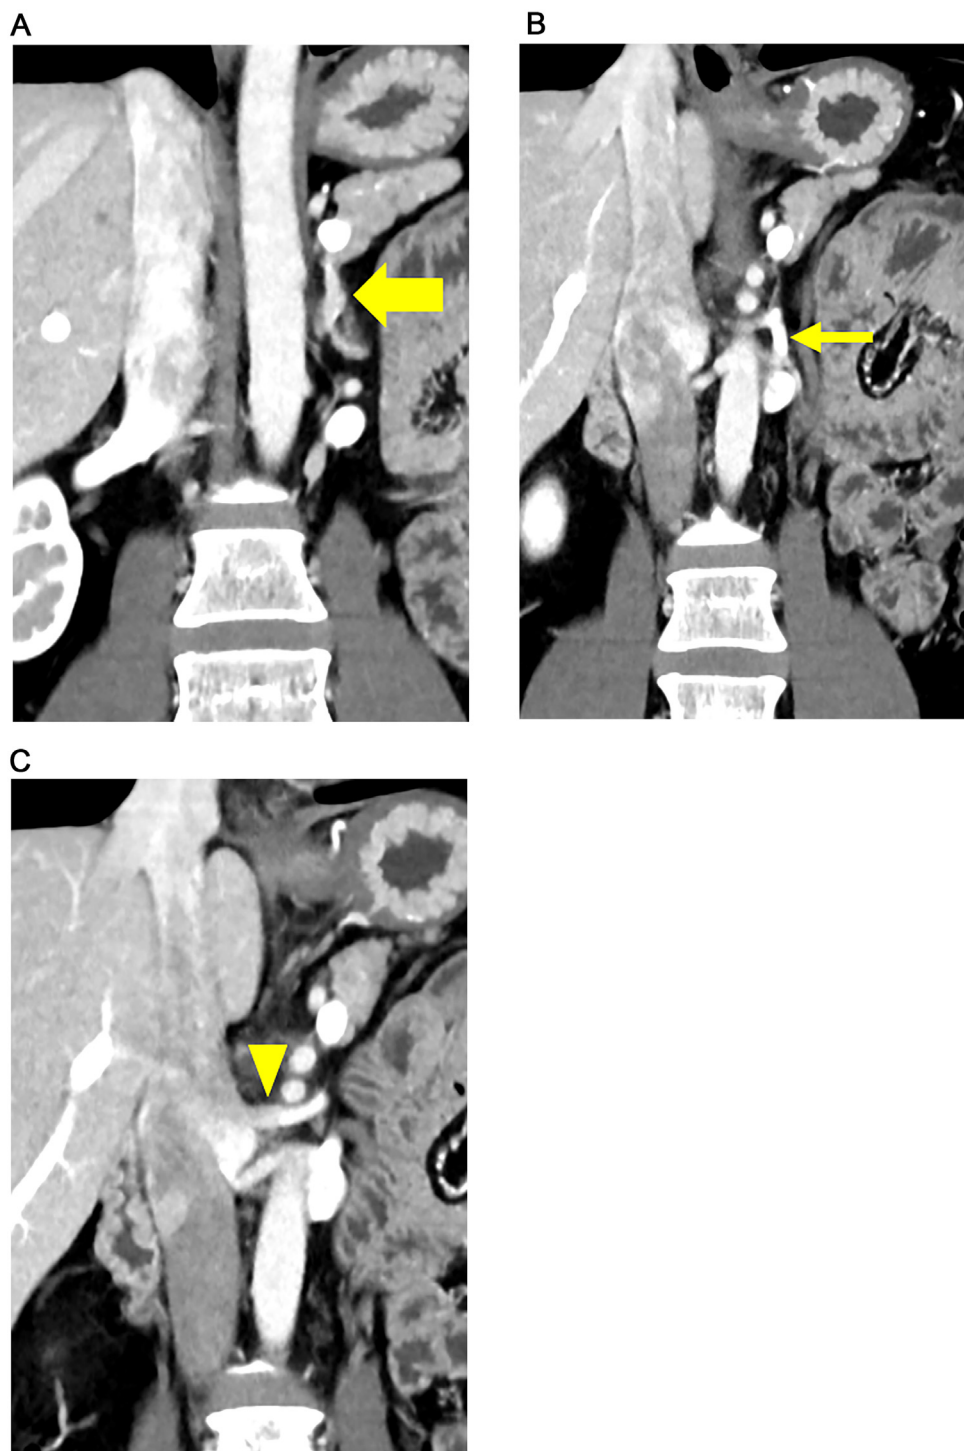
Coronal contrast-enhanced computed tomography images of the abdomen. The left adrenal vein (LAV) drains into both the left renal vein (LRV) and inferior vena cava (IVC). (A) LAV (thick arrow). (B) Branch draining into the LRV (thin arrow). (C) Branch draining into the IVC (arrowhead).
